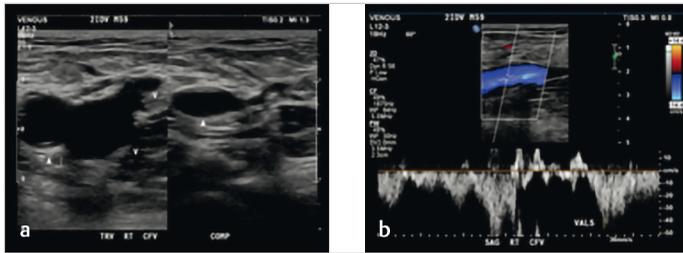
(a) Normal transverse images of the right common femoral vein (CFV) with and without compression. (b) Normal color Doppler and waveform in the right CFV showing normal respiratory variation and Valsalva.
